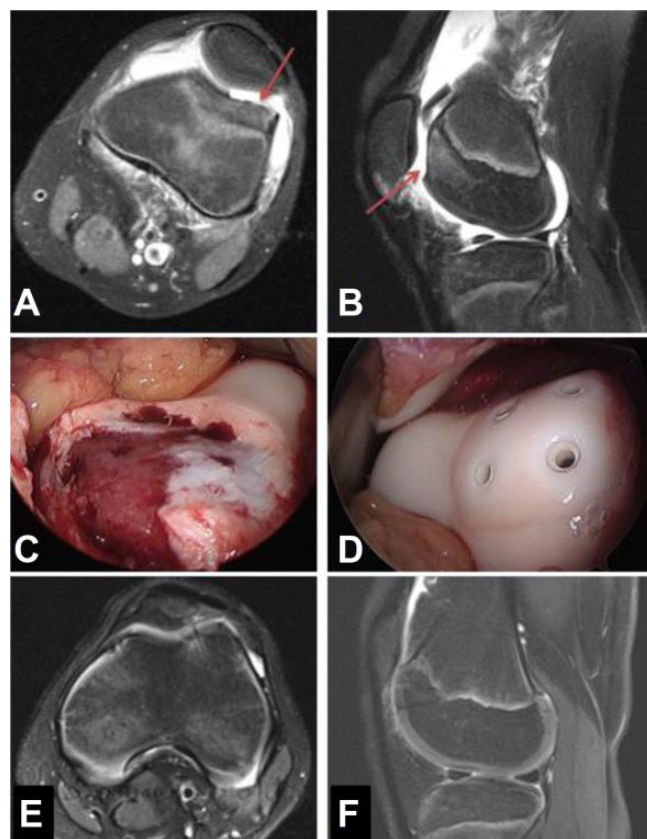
An 11-year-old male patient fell onto a flexed knee. (A) Axial and (B) sagittal T2-weighted turbo spin echo (TSE) magnetic resonance imaging (MRI) sequences with fat suppression (Magnetom Sonata 1.5 T; Siemens) reveal a loose chondral fragment from the lateral femoral condyle/trochlea with maintenance of subchondral bone at the donor site (arrows). Intraoperative photographs show (C) chondral defect on the lateral trochlea and (D) fixation using absorbable tacks and fibrin glue. (E) Axial and (F) sagittal T2-weighted TSE MRI sequences with fat suppression (Magnetom Skyra 3 T; Siemens) obtained 4.5 months postoperatively show early fragment integration and resolution of bone marrow edema.
